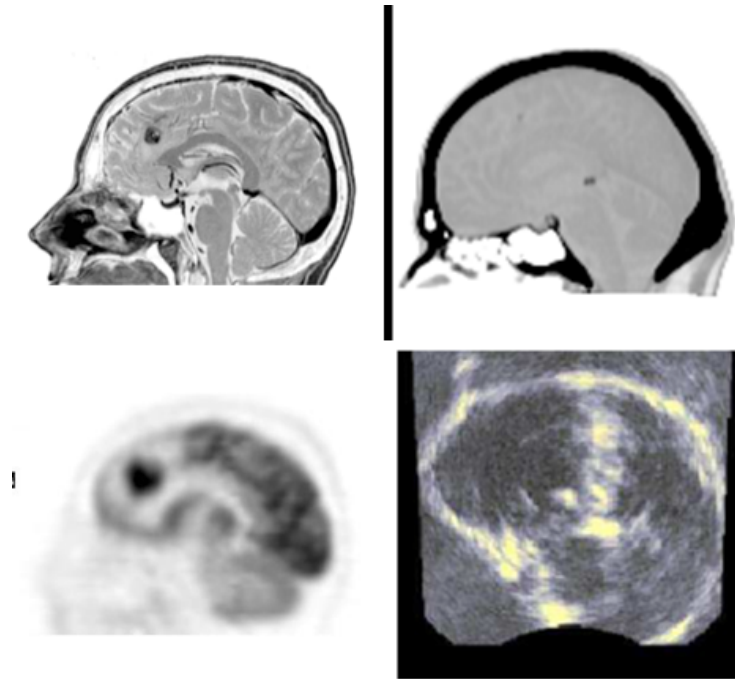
Sagittal slices of the brain obtained using four different medical image modalities. a) magnetic resonance imaging (MRI), b) computed tomography (CT), c) positron emission tomography (PET), d) ultrasound. The figure was adopted from [57].
